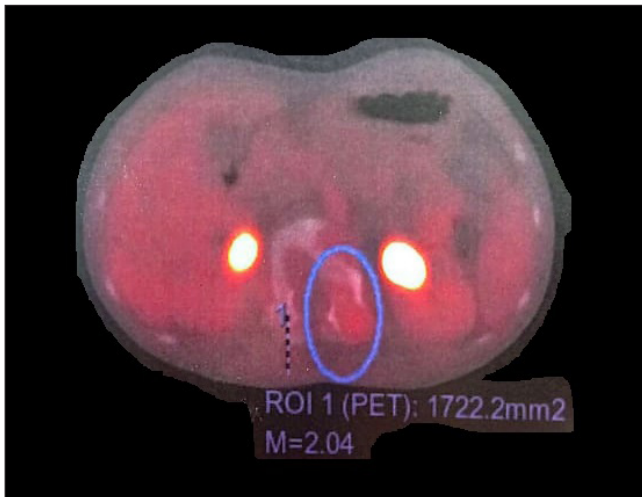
Evaluation revealed a robust morpho-metabolic response. However, the response was classified as incomplete due to residual bone lesions exhibiting FDG uptake levels marginally above the liver background (consistent with a Deauville Score of 4).
